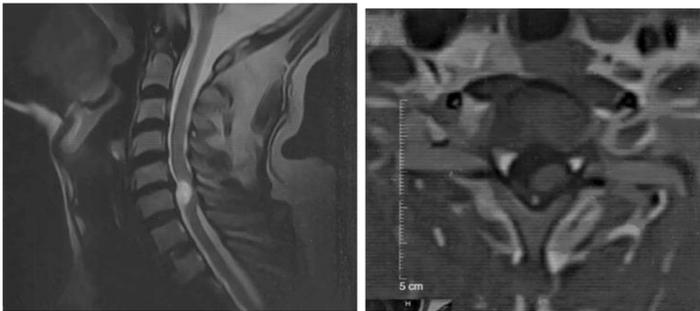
Preoperative magnetic resonance imaging of the cervical spine: (A) sagittal T2-weighted image and (B) axial T1-weighted image showing a hyperintense, oval-shaped intradural extramedullary lesion opposite C5–6, located posterolateral to the spinal cord.
